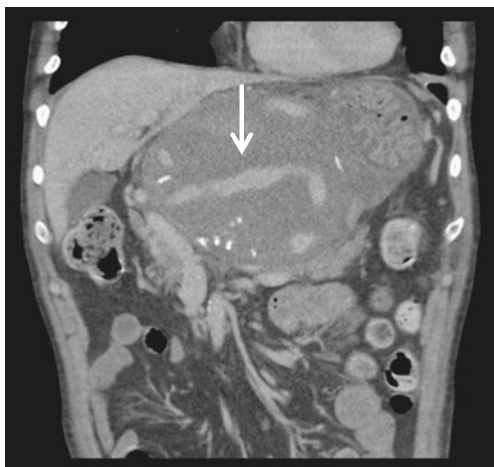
CT angiogram: coronal view of the 18-cm giant splenic artery pseudoaneurysm. Contrast enhancement of blood flow within the pseudoaneurysm is noted. The *arrow* points to the false channel
